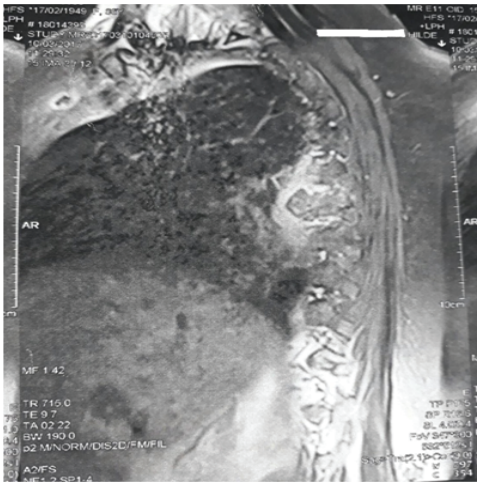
RMN and CT spine scan
